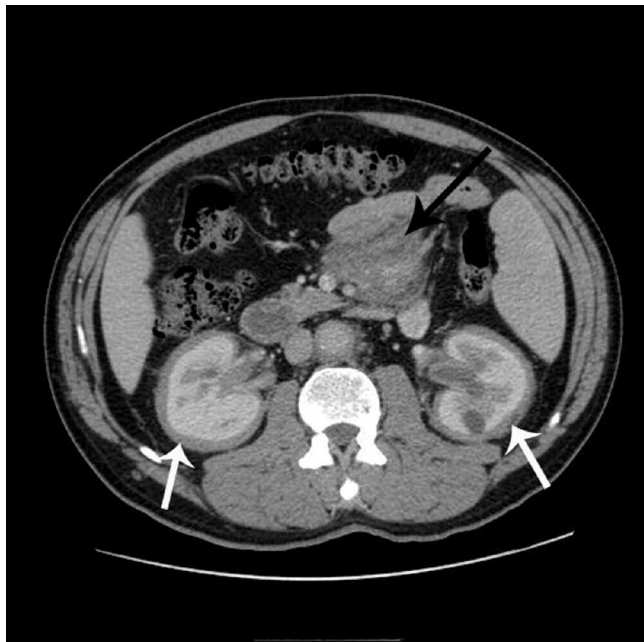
Axial image of a contrast-enhanced computed tomography abdomen scan shows 1-cm soft tissue surrounding both kidneys (white arrows). A soft tissue mass surrounds the mesenteric blood vessels (black arrow).
